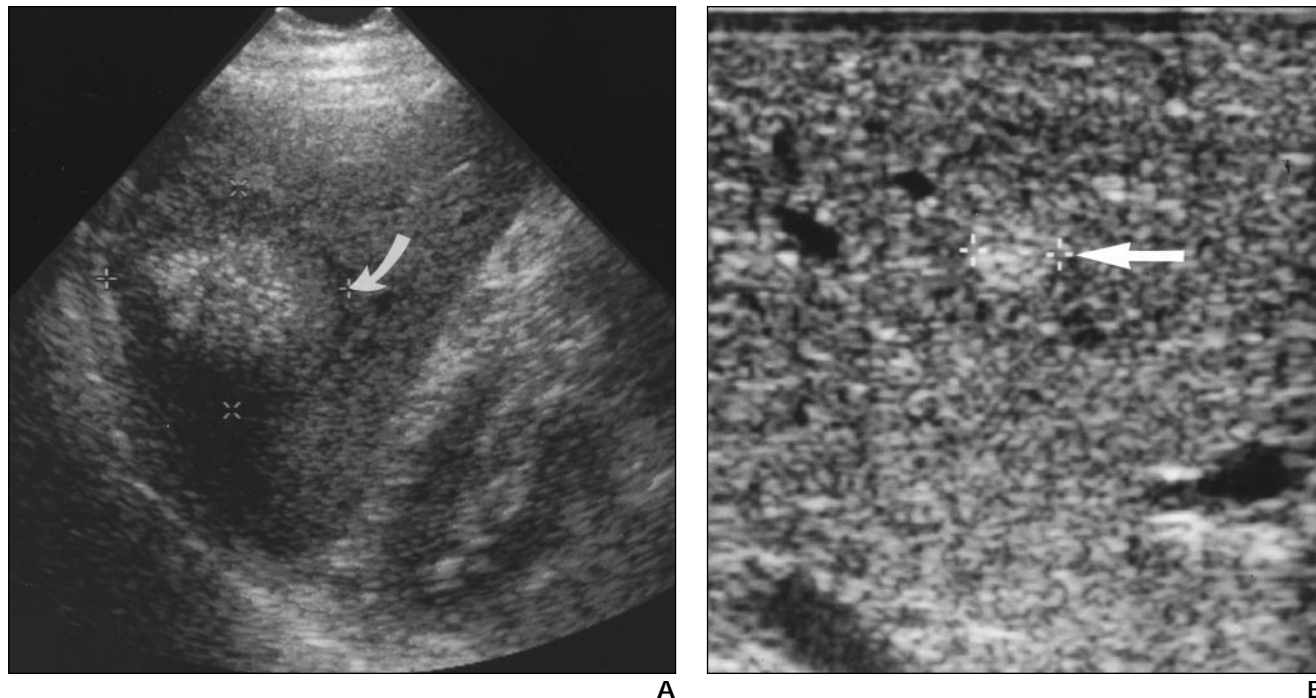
62-year-old man with metastases to liver from colon cancer. A, Both preoperative CT scan (not shown) and sonogram show only a single large metastasis in right lobe of liver (*arrow*) that was scheduled for operative resection. B, At surgery, intraoperative sonography revealed several 4-mm metastases scattered throughout liver (*arrow*). Resection was not performed.
